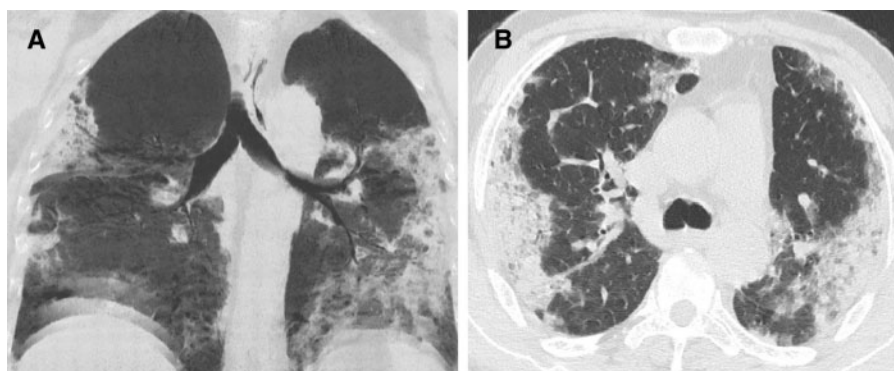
(A, B) Coronal and axial CT images of the thorax depicting bilateral peripheral consolidations with sparing of central region consistent with Reverse Batwing appearance.
